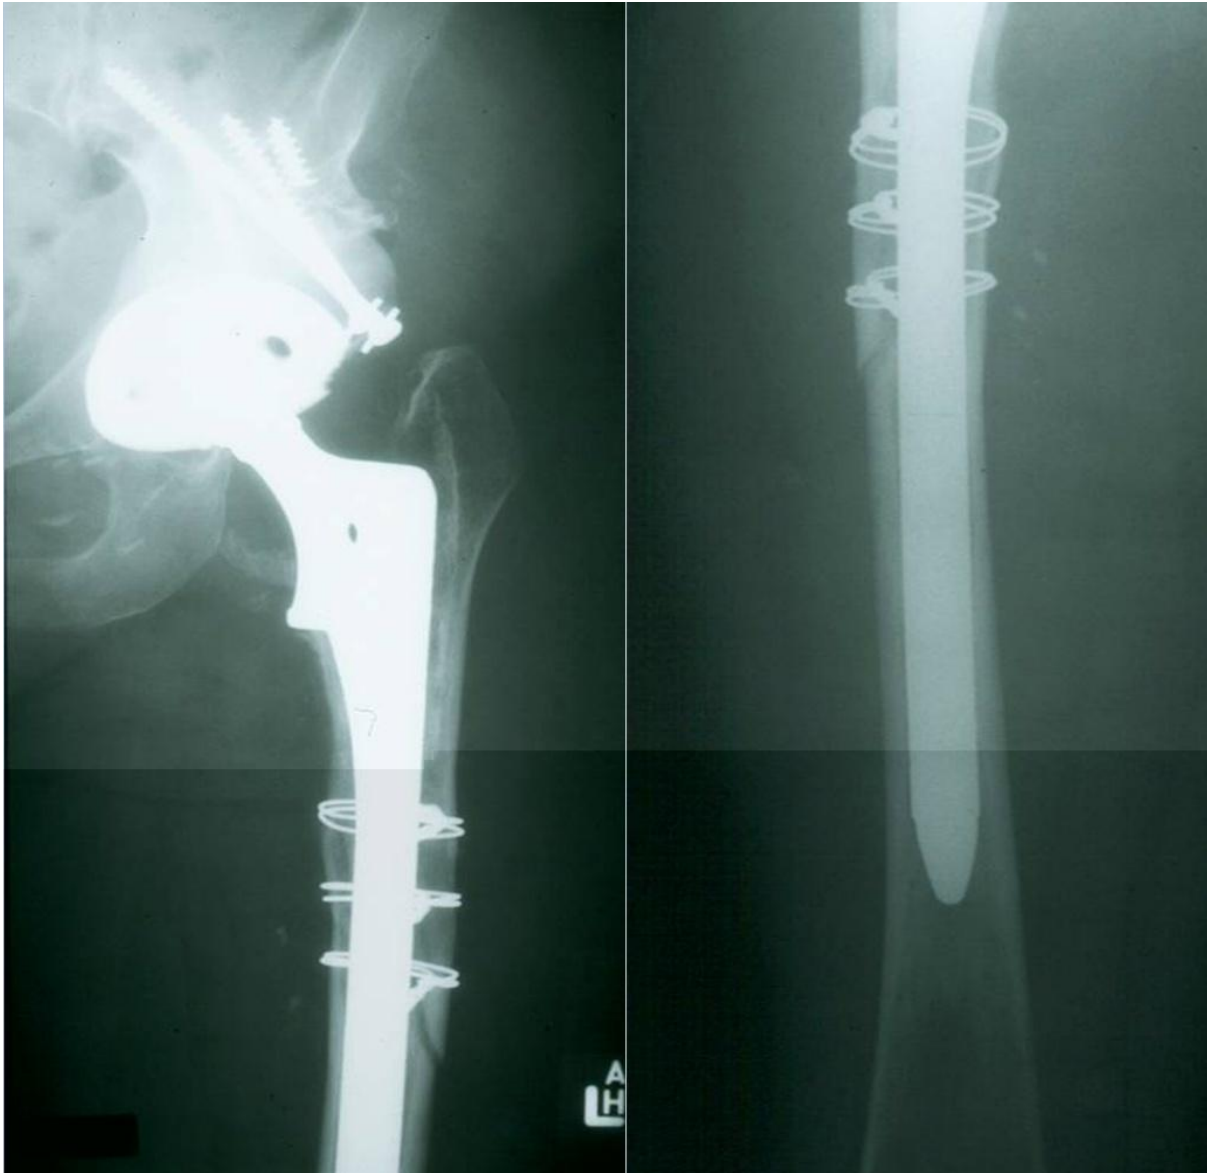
AP radiographs of the left femur showing fixation of a Type B2 fracture with a long-stemmed extensively coated implant supplemented with three cerclage wires
